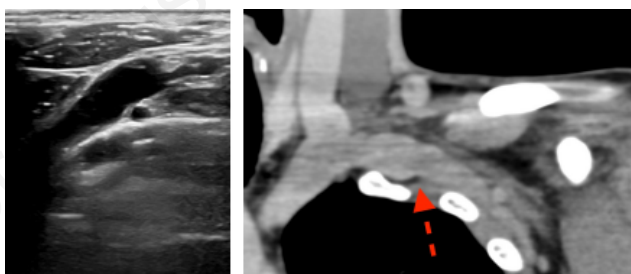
Left: high-resolution ultrasound image of the change in diameter of the right subclavian vein. Right: corresponding Magnetic Resonance (MR) image (red arrow).
